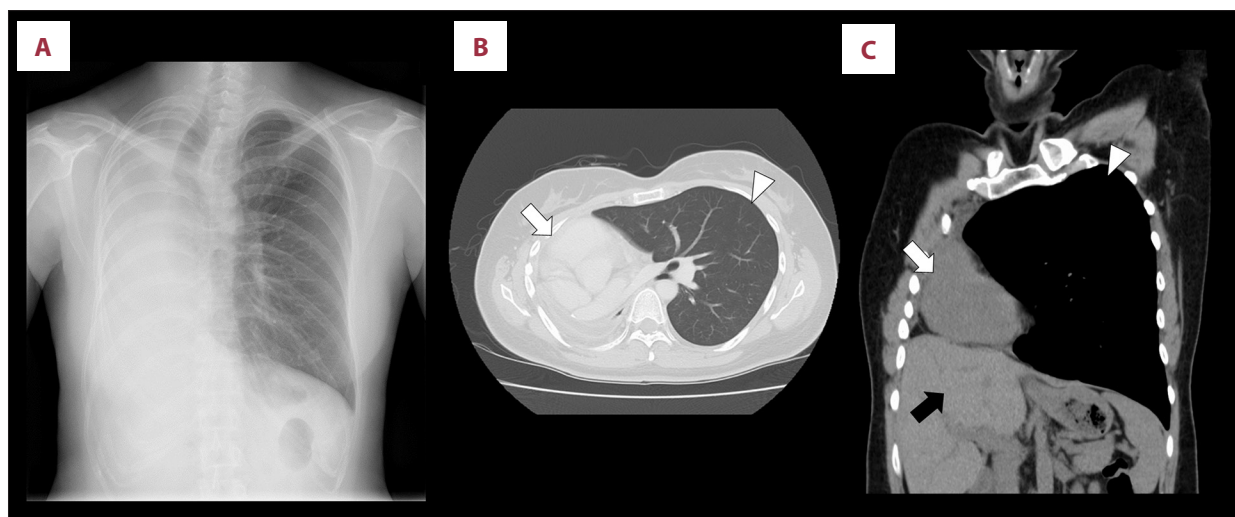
Chest images after pneumonectomy. Chest radiographs show the mediastinum shifting into the right pleural space (A). Chest computed tomography images on axial views (B) and coronal views (C). The left lung is overinflated (arrow) and the heart is shifted into the right space (white arrow). The hemidiaphragm and the liver are elevated (black arrow).
